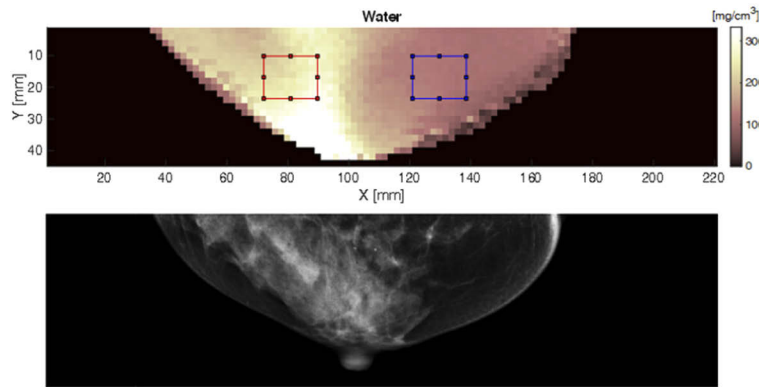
Water map of subject #2 (a) and corresponding x-ray mammogram (b), CC R view. The red and blue rectangles identify the composition-based ROIs selected as representative of the outer and inner quadrant, respectively.
